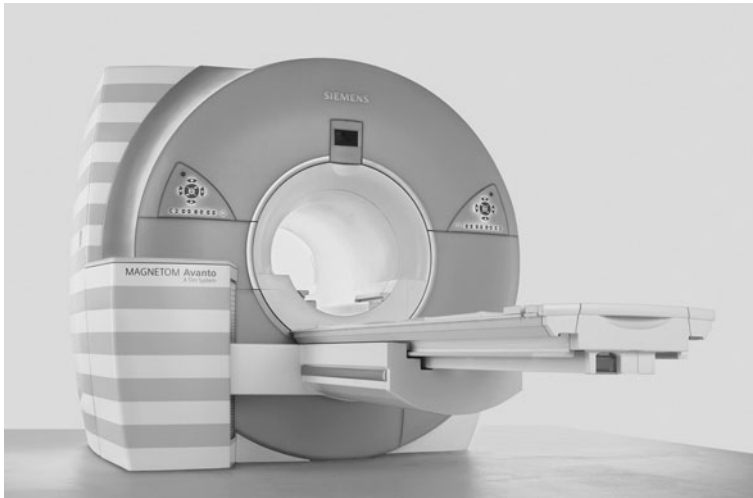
Gantry of an MR imaging device (Magnetom Avanto, with kind permission from Siemens Sector Healthcare, Erlangen, Germany). Images can be produced at arbitrary angles with respect to the gantry by producing appropriate slice selection gradients
